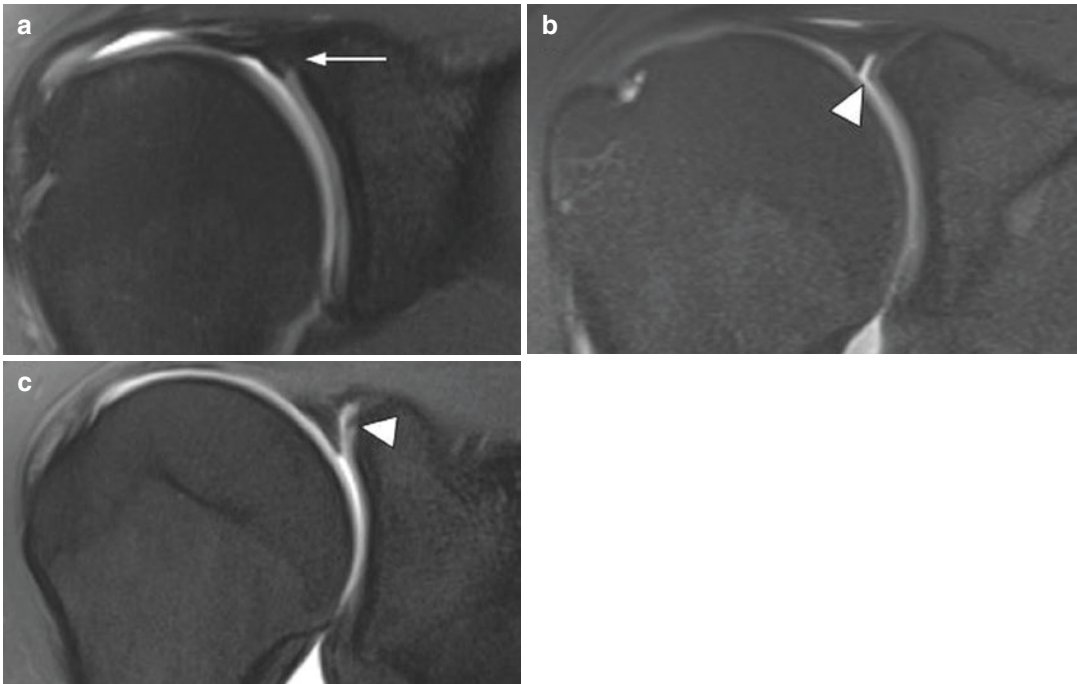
Biceps labral complex (BLC). Coronal fat-suppressed T1-weighted MR arthrographic images demonstrate the three distinct types of biceps labral complexes. (a) Type I BLC with firm attachment of the labrum to the underlying glenoid cartilage without cartilage undercutting or sublabral recess (arrow). (b) Type II
